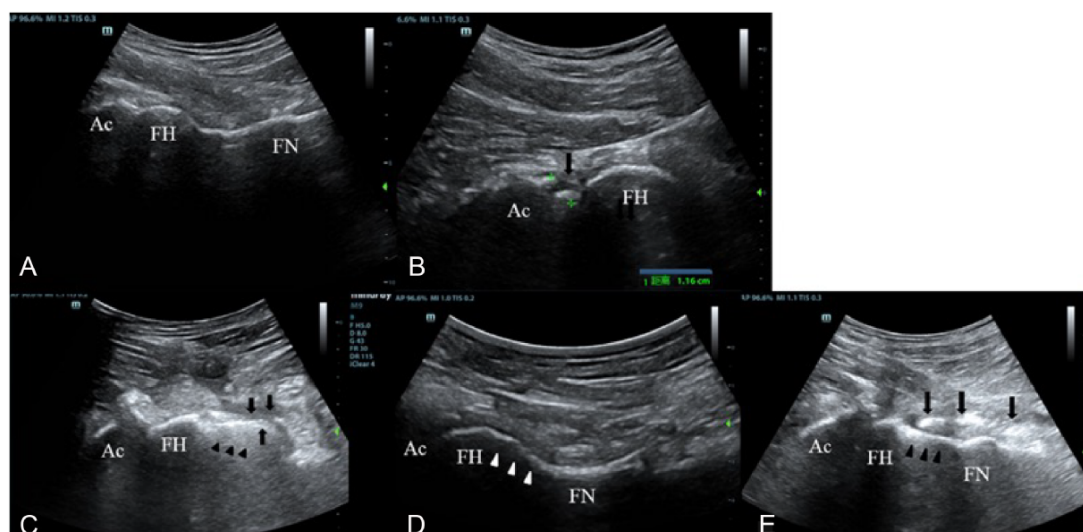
Example of intraoperative ultrasound. (A) The acetabular and femoral head were in contact before traction. (B) After traction, the distance between the acetabular and femoral head increased, and an air-like hyper-echo (arrow) was found under the joint capsule. (C) Air that had accumulated inside the joint capsule interfered (arrow) with the observation of the FHNJ (arrowhead). (D) Preoperative ultrasound of the FHNJ shows asphericity (arrowhead) of the FHNJ, indicating the existence of FAI. (E) Intraoperative ultrasound showed the morphology change of the FHNJ (arrowhead). The cam deformity was removed, and an air-like hypo-echo (arrow) occurred inside the joint capsule.
